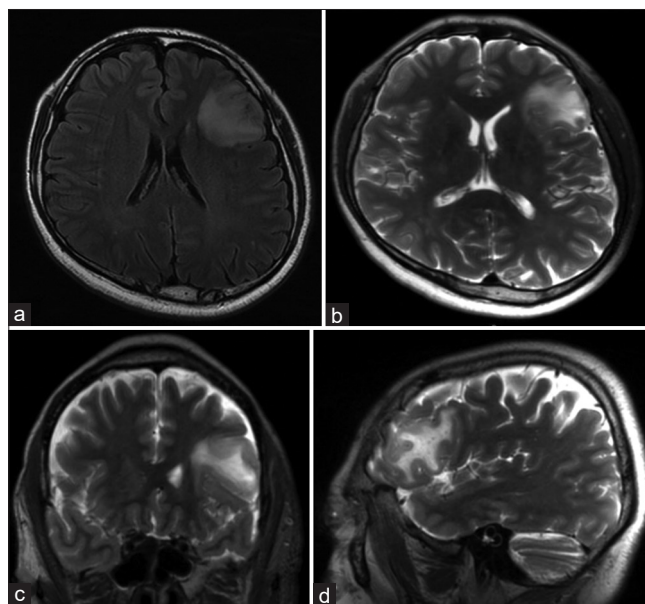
Preoperative magnetic resonance imaging (MRI) showing (a) the tumor was confined to pars triangularis and pars opercularis, (b) Preoperative axial, (c) coronal, (d) sagittal and T2 MRI scan showing the posterior part was in contact with the central gyrus.
